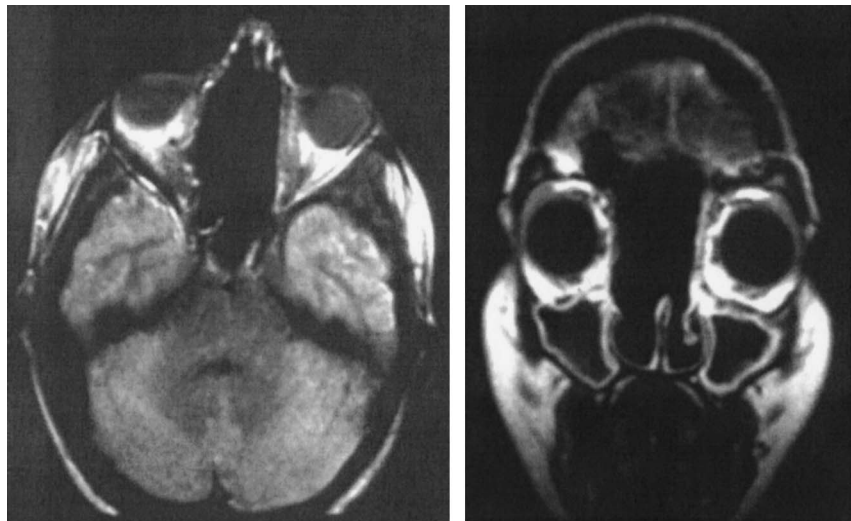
Postoperative (A) axial and (B) coronal MR images of the same patient showing the complete removal of the tumor.
